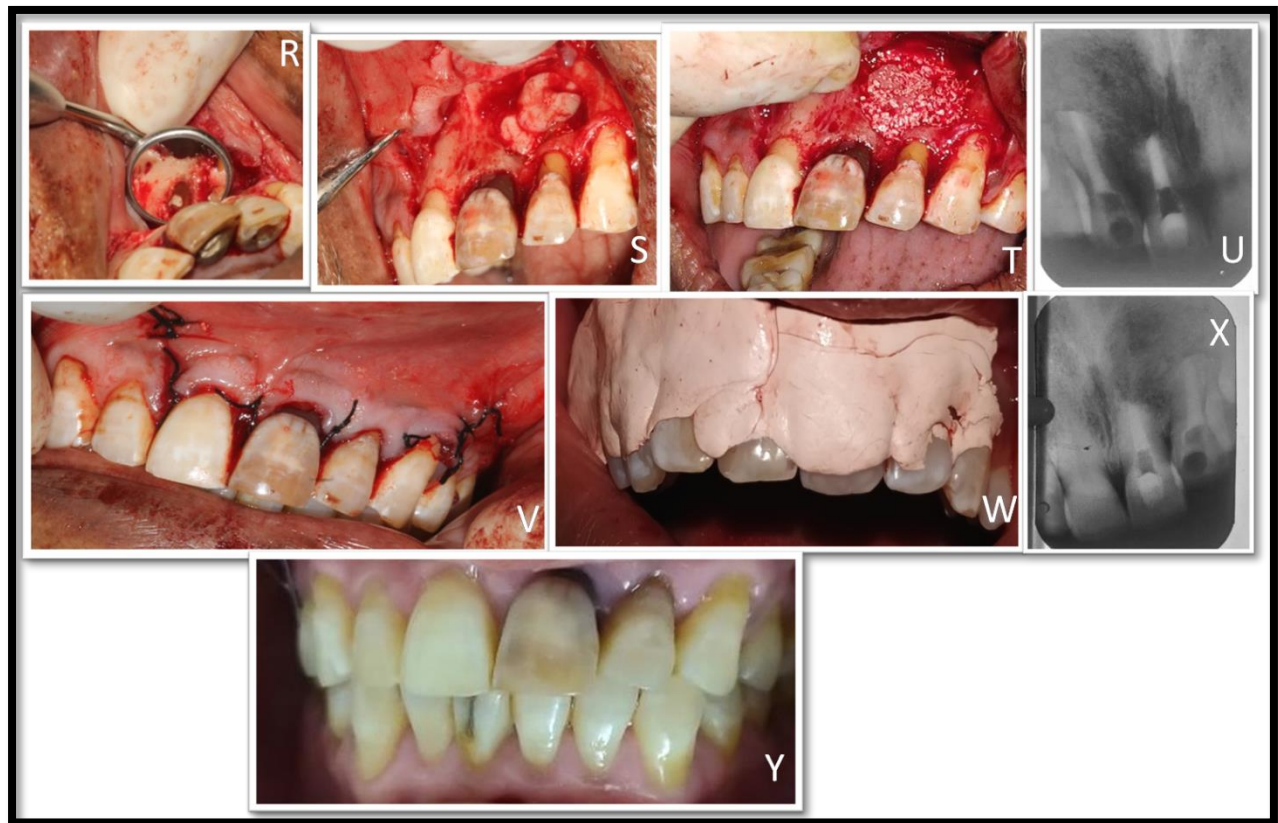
R) Exposure of root end , S) PRF placement, T) Cortical bone and bone graft placed, U) Post operative radiograph, V) Single interrupted sutures taken, W) Periopack placed, X) 3months follow up radiograph, Y) 12 months follow up.
